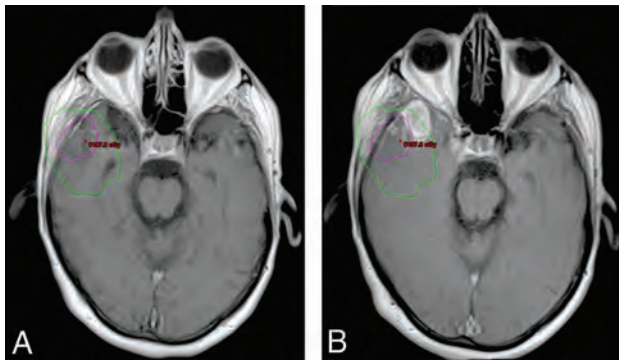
Delineation of the radiation therapy target for the treatment of a gross totally resected GBM in the right temporal lobe and its relation to tumor recurrence. *A*, Fused planning CT and axial contrast-enhanced T1-weighted postoperative image allow visualization of the radiation dose effectively delivered in the brain parenchyma adjacent to the surgical cavity (isodose chart). The high-dose region is defined as the area inside the *pink line*, corresponding to the 100% isodose line (60 Gy) plus the area between the *pink* and *green lines*, corresponding to the 80% isodose line (48 Gy). *B*, Fused planning CT and axial contrast-enhanced T1-weighted follow-up images demonstrate that a significant portion of the new enhancing lesion was located outside the high-dose radiation field (inside the *green line*), which is consistent with progressive disease.
